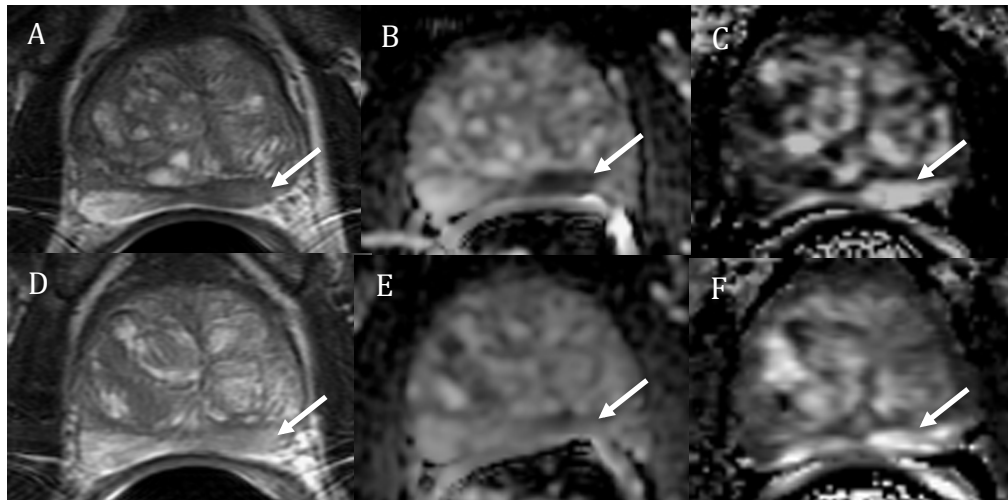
A 74 year-old male with serum PSA of 10.3 ng/ml who underwent radical prostatectomy. Top panel: dense GS4+3 cancer (60% cancer): a) coil-corrected T2-weighted image, b) ADC map c) maximal enhancement slope. Bottom panel: sparse GS4+3 cancer (30% cancer): d) coil-corrected T2-weighted image, e) ADC map f) maximal enhancement slope. The arrows designate cancerous regions.
